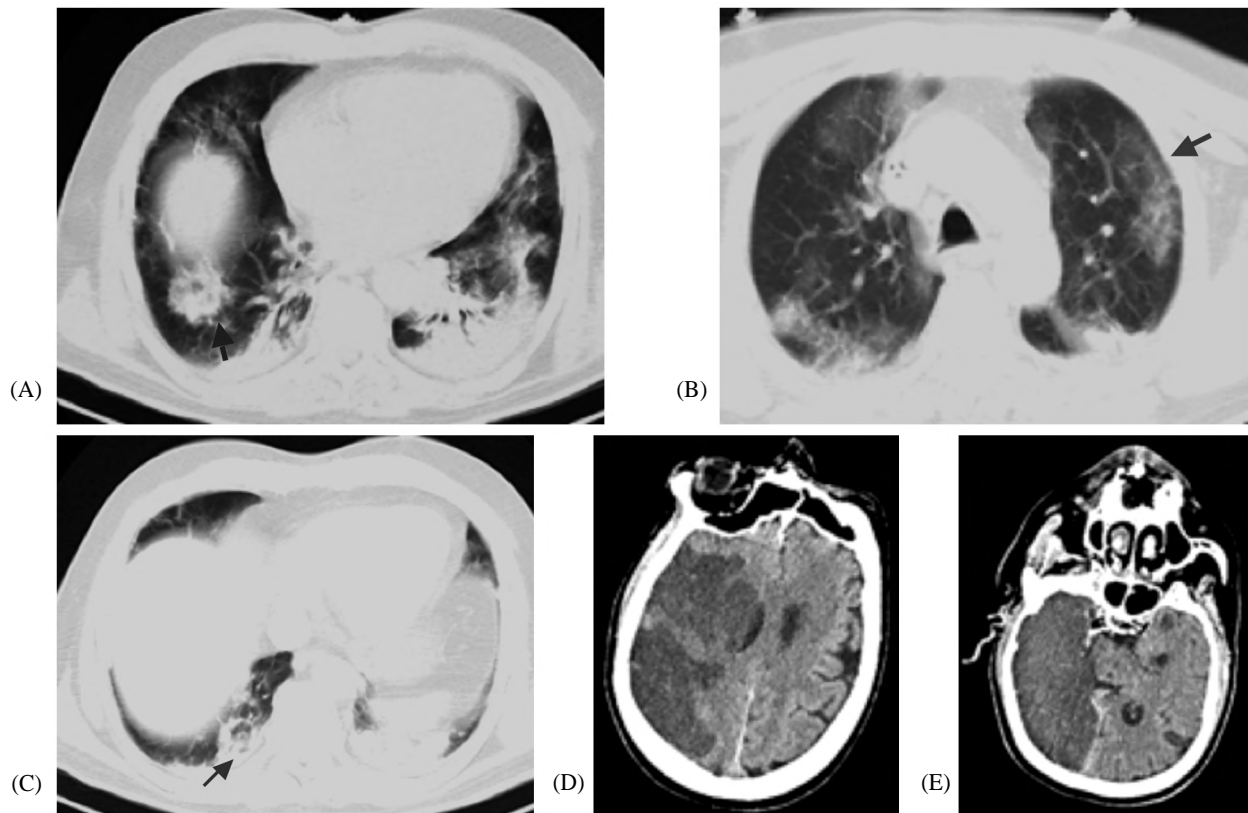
60 years old male patient with progressive dyspnea, respiratory distress followed by left sided weakness and disturbed conscious level. (A,B and C) Axial CT chest lung window, CT severity score 19, showing a toll sign in (A), crazy paving pattern in (B) and bull's eye sign in (C). (D,E) Axial CT of the brain showing right fronto-temporo-parietal large acute ischemic infarction along right MCA territory.
